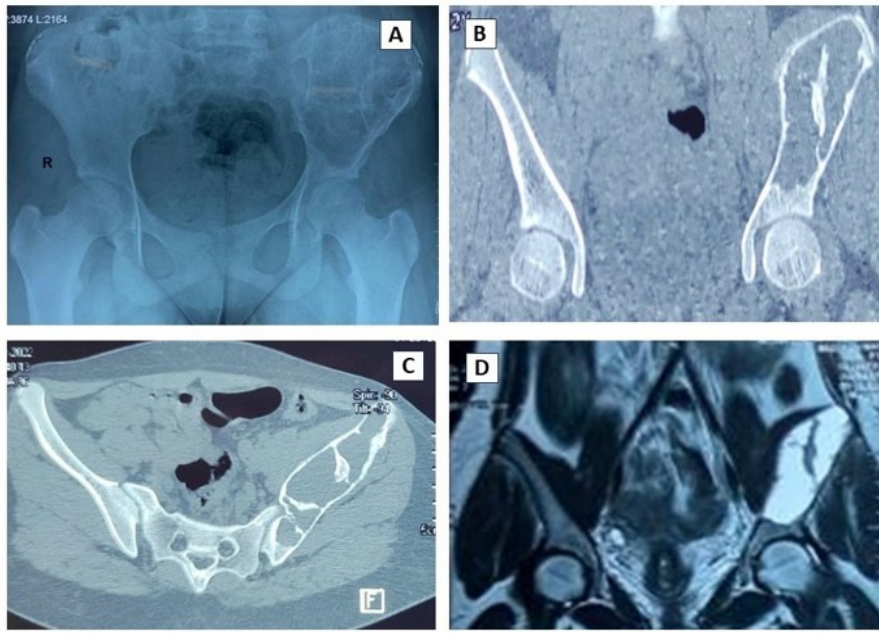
X-ray shows a lytic lesion involving the left pelvis (A), which is ballooning with peripheral thinned cortex appreciated on the CT scan (B and C), MRI showing the classical multiple fluid levels (D).
